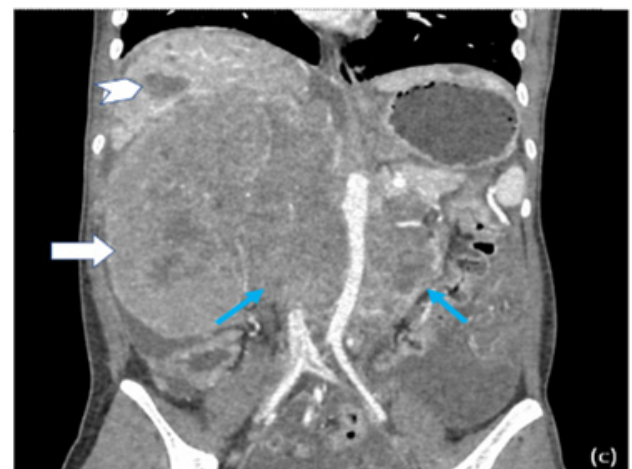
Treatment reassessment scan - Post pazopanib progression CT shows larger renal tumour (white arrow) with worsening paraaortic lymphadenopathy (blue arrow) and new liver metastasis (arrowhead).
